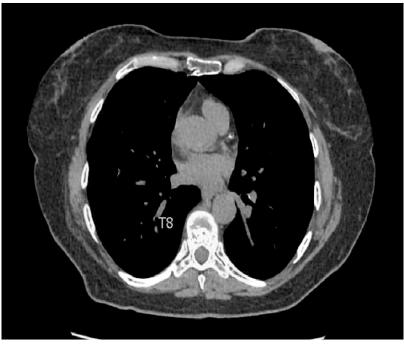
CT chest without contrast showing anterior wedge compression deformity of the body of T8.
